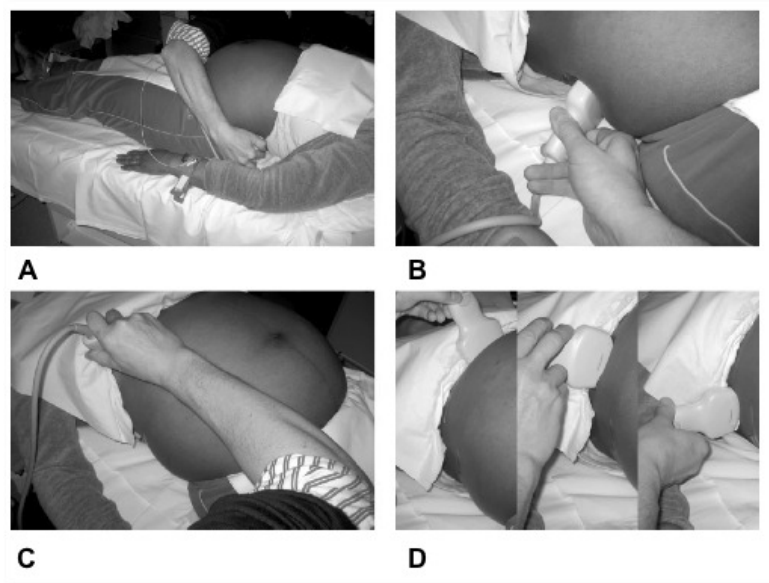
Scanning technique used to study HV and RIV flow in pregnant women as reported elsewhere [94, 93, 147]. The woman is examined in the supine position. The ultrasound probe is placed in a transverse position at each loin to capture three measurements per kidney (A, B). Similarly, each of the three main branches of the HV is assessed once, after intercostal positioning of the ultrasound probe at the level of the right epigastrium (C) at 11 o'clock (left HV), 10 o'clock (middle HV) and 9 o'clock (right HV) (D) positions.
